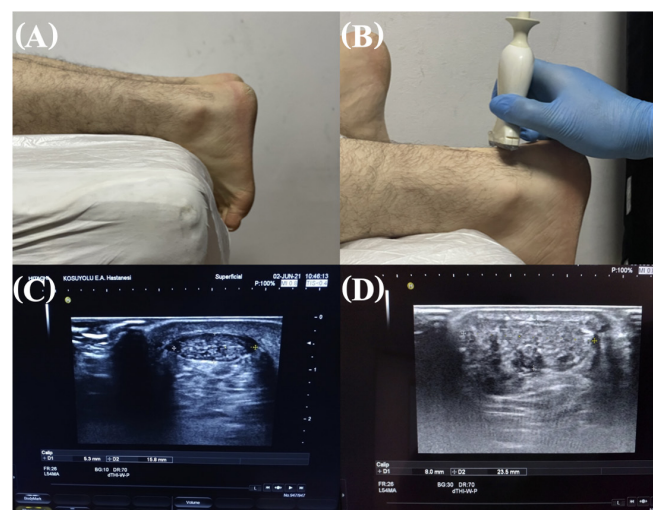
Position of patient and probe in Achilles tendon thickness measurement. (A). Achilles tendon imaging was performed with the patient prone position and ankles extended from the examination stretcher. (B). To facilitate contact between the probe and the tendon, the probe was positioned by bending the ankle slightly by 90 degrees. (C). Measurement of Achilles tendon thickness (5.3 mm) and width (15.8 mm) in transverse section. (D). Achilles tendon ultrasonography of a patient with familial hypercholesterolemia and stent restenosis on carotid DUS. The thickness (8 mm) and width (23.5 mm) of the Achilles tendon have increased, the fibrillar structure of the tendon has deteriorated, and a type 3 sonographic pattern with nodular xanthomatous appearance is observed.
